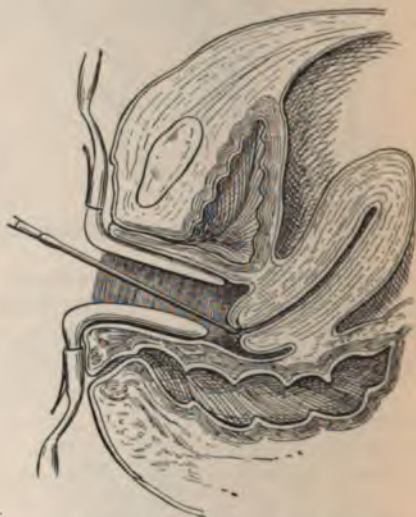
INDIRECT INSPECTION OF THE UTERUS. Shows the cervix being drawn into the lumen of the speculum with a tenaculum.
